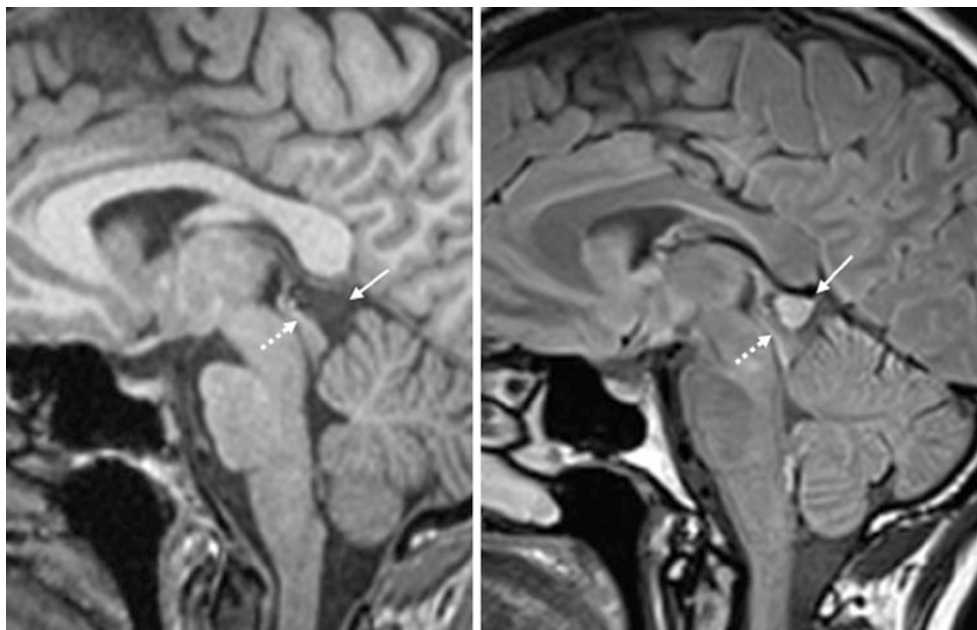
A 55-year-old patient with a routine research 3 T MRI. An incidental 11 mm pineal cyst (*thin arrows*) slightly compressed the tectum (*dotted arrows*), as shown on 1-mm thickness sagittal T1WI (*left*)
